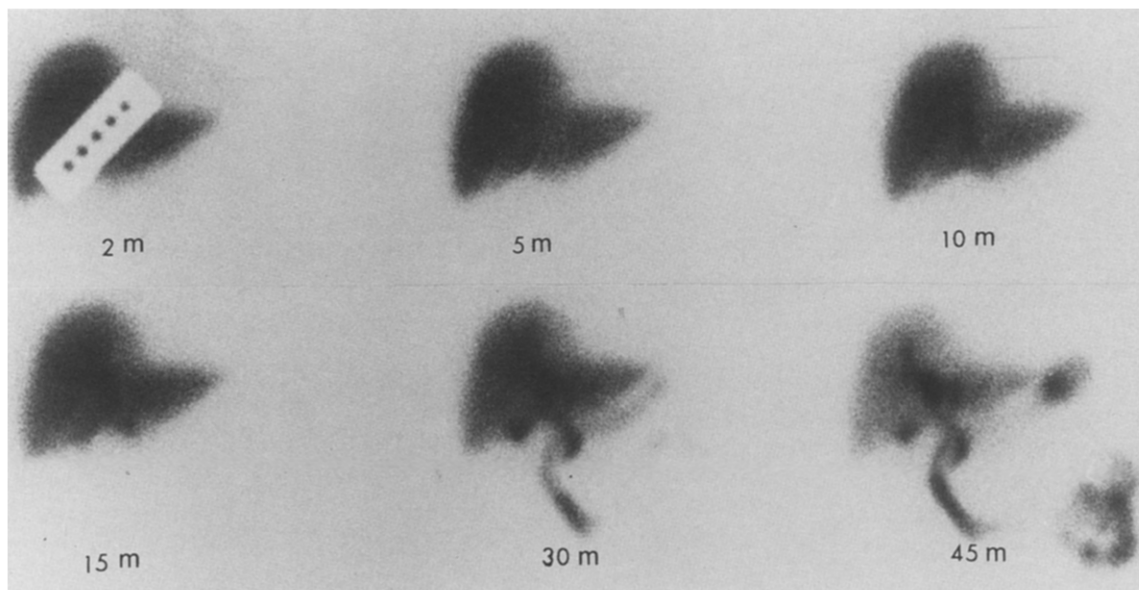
^{99m}Tc -DISIDA hepatobiliary scintigram of patient 2 shows normal radiopharmaceutical accumulation in the liver and gallbladder activity beginning at 15 minutes and bowel activity at 30 minutes. At 45 minutes a small amount of radiotracer is seen in the stomach region.
